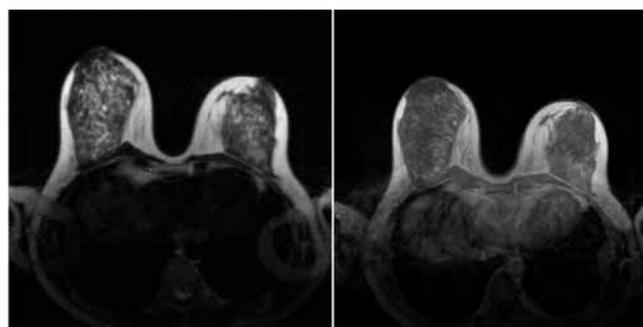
MRI of both breast after operation
